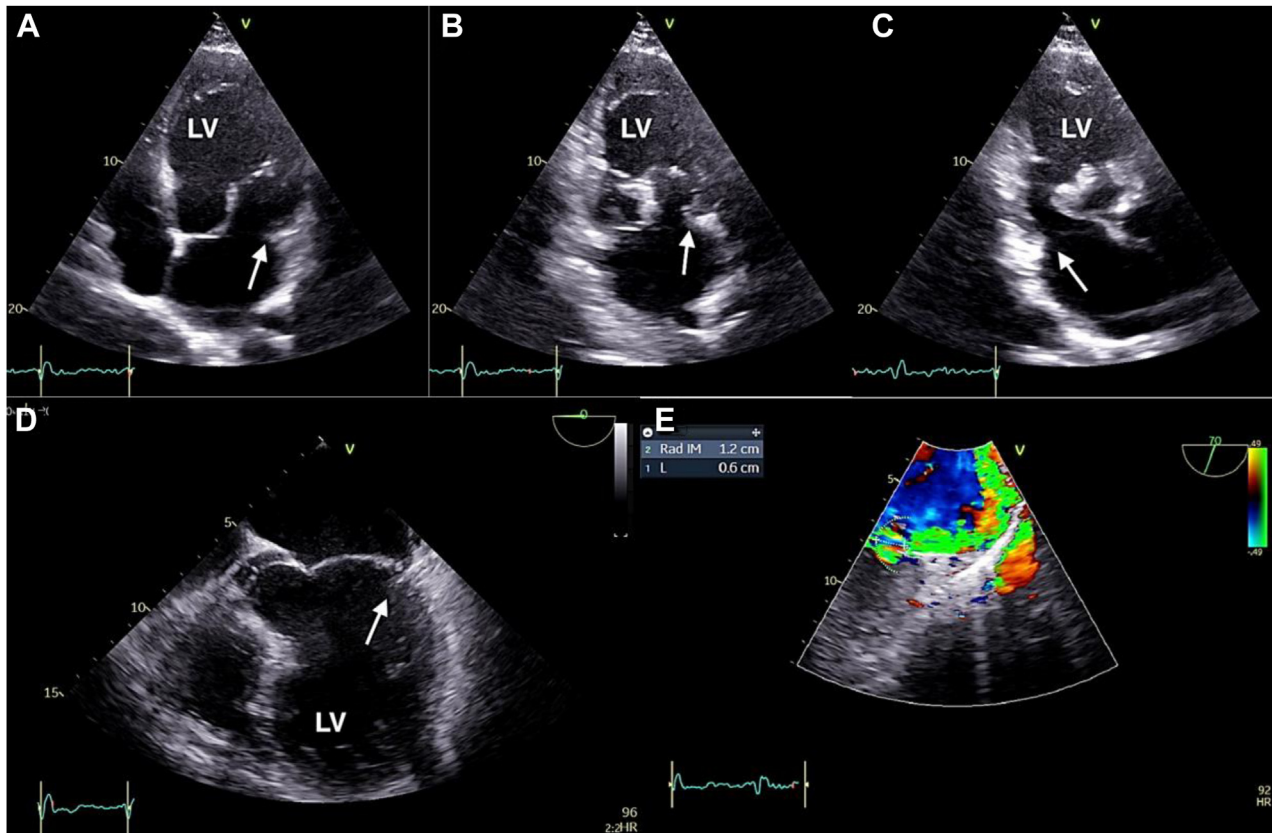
(A) Two-dimensional TTE, apical 4-chamber diastolic view, demonstrates the redundant anterior mitral leaflet with the HPMVL (arrow). (B) Two-dimensional TTE, apical 2-chamber view, mid diastole, demonstrates the poorly developed posterior leaflet with restricted motion (arrow). (C) Two-dimensional TTE, apical 3-chamber view, early diastole, demonstrates the barely visible posterior leaflet (arrow). (D) Two-dimensional TEE, 4-chamber (0°) view, demonstrates the large anterior MV leaflet extending to the lateral annulus and the HPMVL (arrow). (E) Two-dimensional TEE, midesophageal, oblique 2-chamber (70°) view with color-flow Doppler, demonstrates an eccentric MR jet toward the anterior left atrial wall with a moderate vena contracta and PISA radius.
